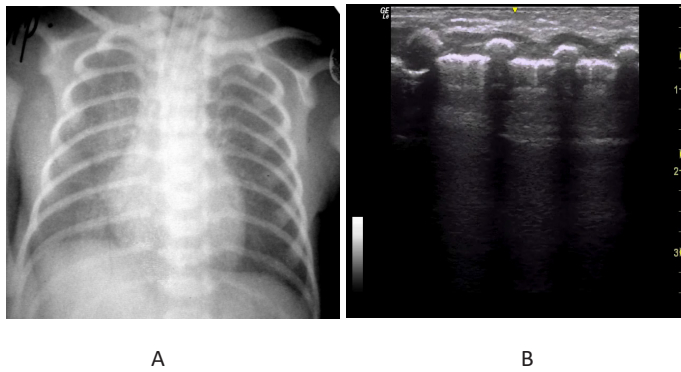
Newborn, gestational age 34 weeks. Respiratory distress syndrome of II degree. A. X-ray reveals a blurred pulmonary pattern with the presence of isolated small focal shadows. B. An ultrasound reveals 2 B-lines (arrows).
